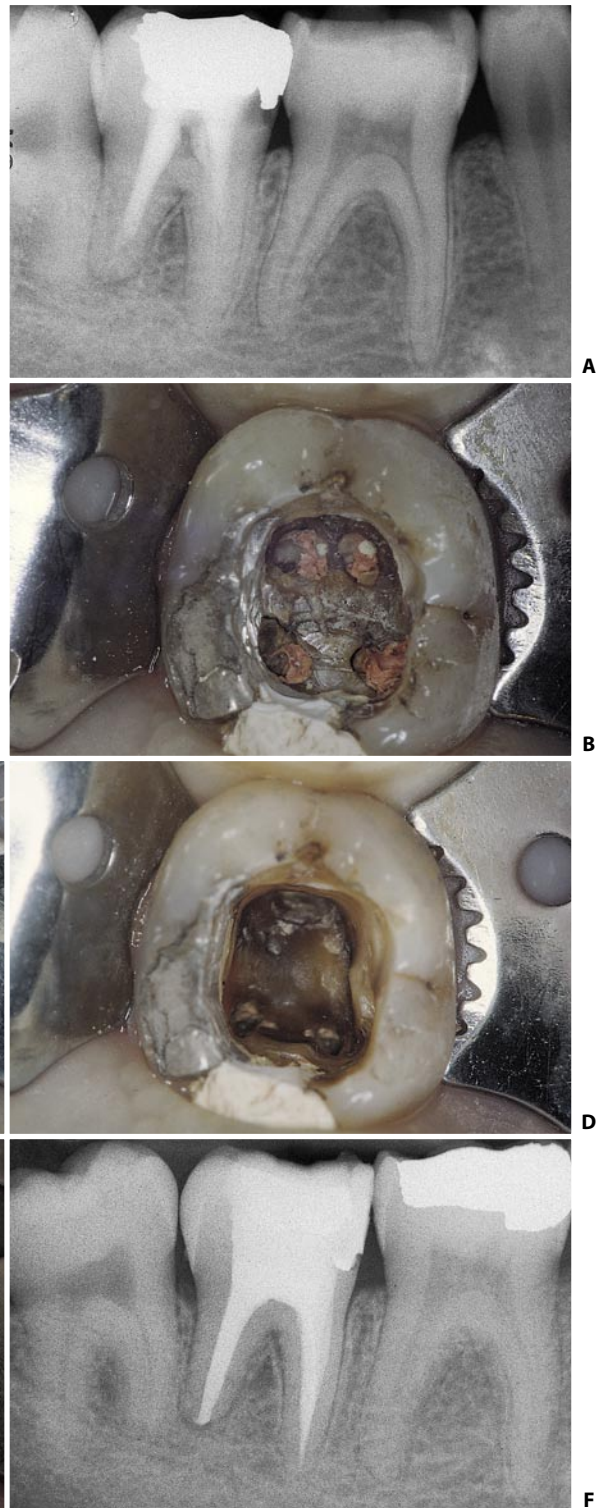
A. Preoperative radiograph. The relatively radiolucent space between the base of the canal obturation and the pulp chamber raises the suspicion of the presence of a residuum of the pulp chamber roof. B. The previous endodontic therapy had been performed through four small holes made in the roof of the pulp chamber. The four pulp horn were interpreted as canal orifices. C. Once the obturating material has been removed with the help of ultrasonics, the chamber roof left in place is better visualized. D. The access cavity has been corrected with the complete removal of the roof of the pulp chamber. E. The same access cavity after preparation of the root canals. F. Post-operative radiograph.
